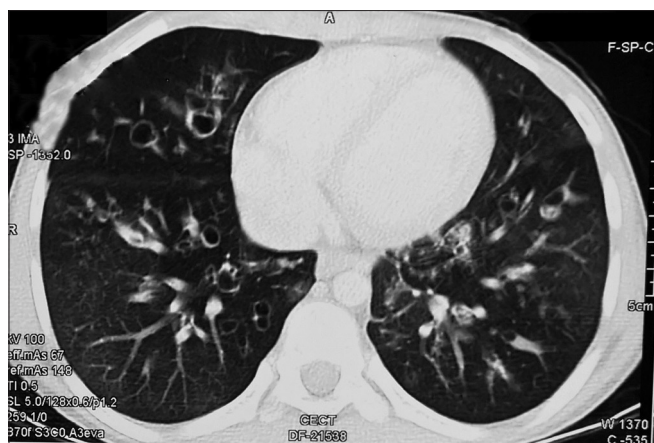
A computed tomography chest in child with allergic bronchopulmonary aspergillosis showing bronchiectasis
